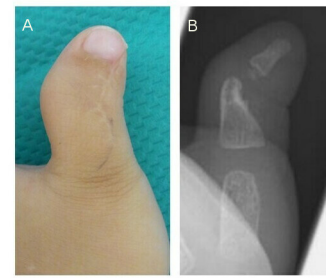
(A) Appearance and (B) radiograph 1 year and 9 months after the initial surgery. The angulation of the interphalangeal joint reached 50°.
